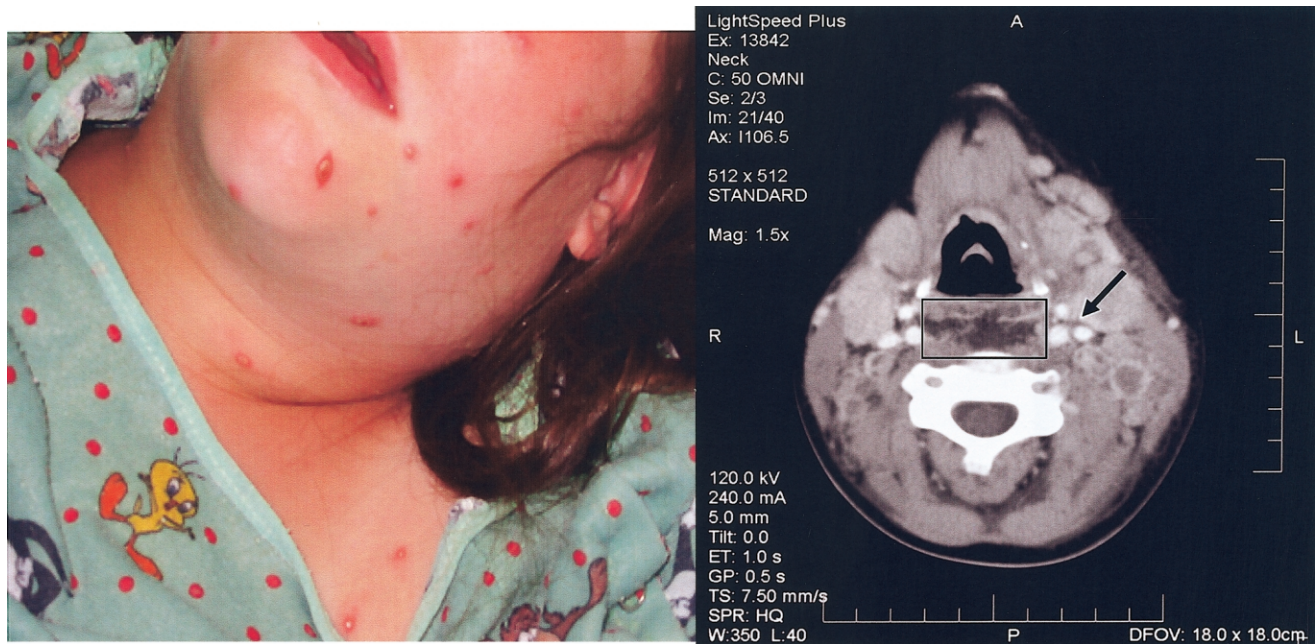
Physical (*left*) and radiographic (*right*) characteristics of monkeypox infection for a girl aged 10 years with a retropharyngeal abscess, tracheal impingement, and cervical lymphadenopathy, United States, 2003.
